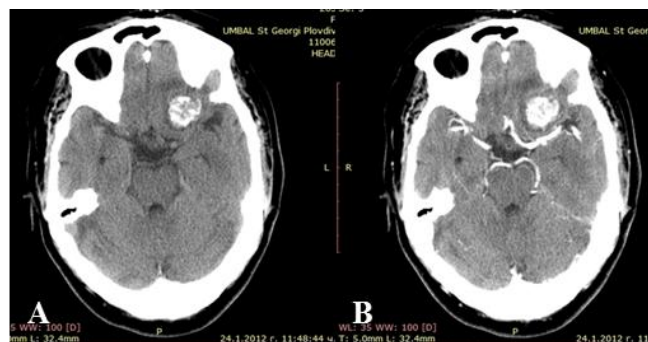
CT image before (A) and after (B) contrast enhancement of meningioma of the lesser wing of the sphenoid bone.
